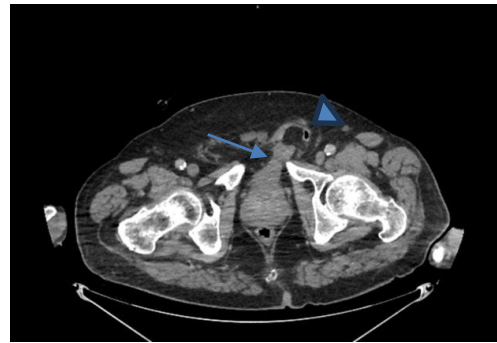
An axial CT image shows the herniated bladder into the left inguinal canal (long arrow). Colon herniation is also seen in the hernia sac (arrow head).
